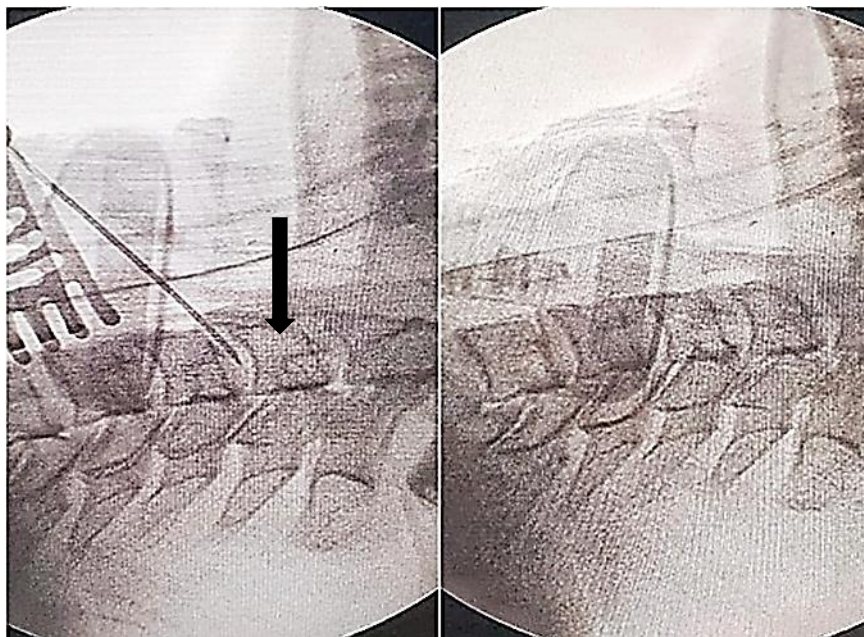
C spine X-ray lateral views (A) Pre-operative showing ACOs (B) post-operative view following osteophyte resection
